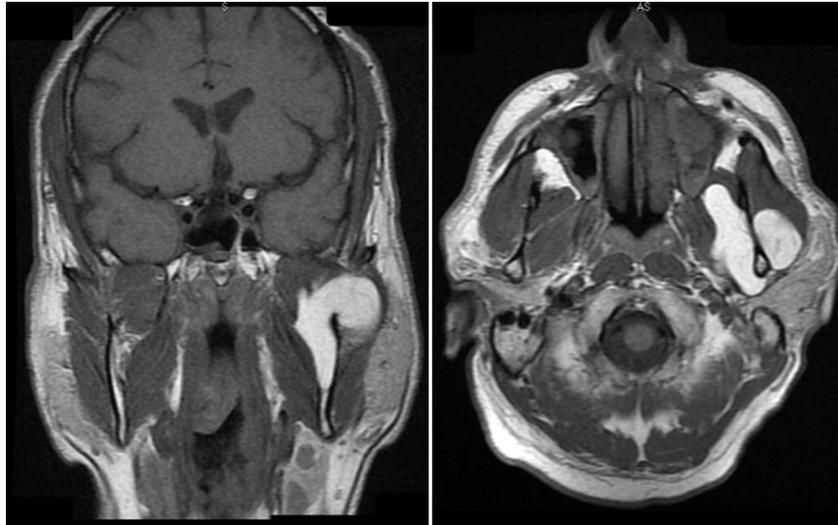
Preoperative Magnetic resonance imaging: showing a mass of 44 mm × 29 mm in the left masticator space (T1-weighted image).
